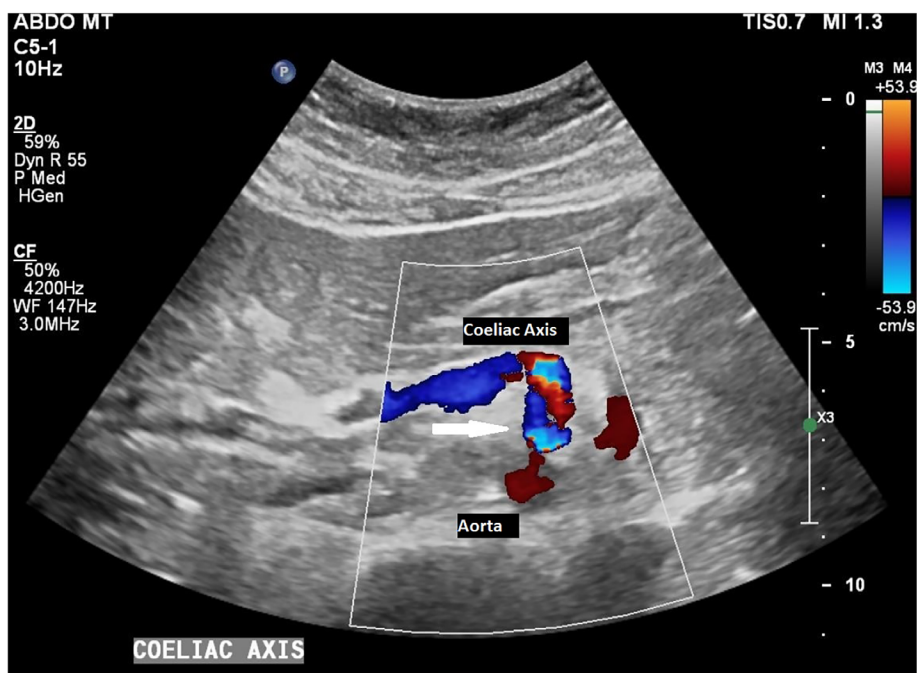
(A) Long axis of aorta with coeliac axis origin and superior mesenteric artery (SMA) origin bifurcate from the aorta anteriorly. (B) Normal long axis of aorta with coeliac axis origin and SMA origin in colour Doppler. (C) Normal coeliac axis to aorta angle.
